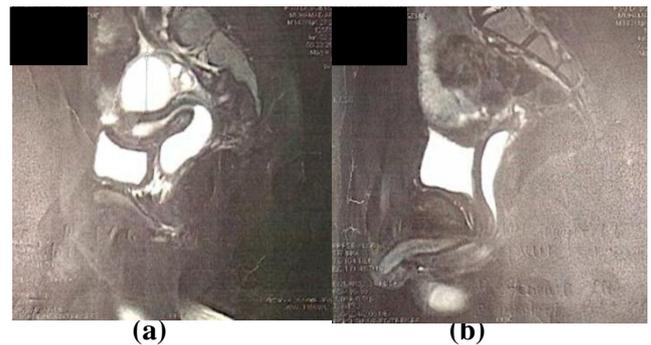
Sagittal view of pre-operative magnetic resonance imaging (June 2017), revealing (a) right testis and male urethra connecting the urinary bladder to the penis; (b) a vagina and anteflexed uterus with fluid retention.
